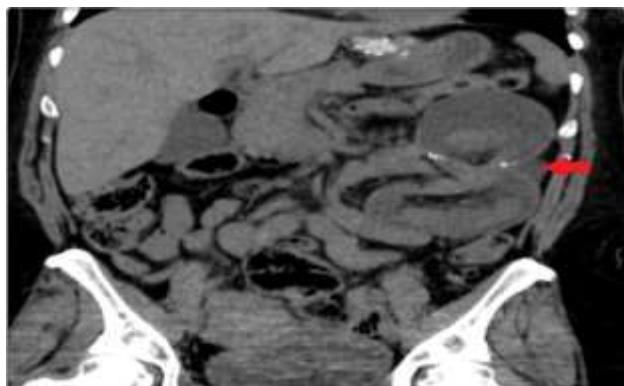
Coronal view of intestinal intussusception close to the anastomosis (arrow) as seen on CT scan.
